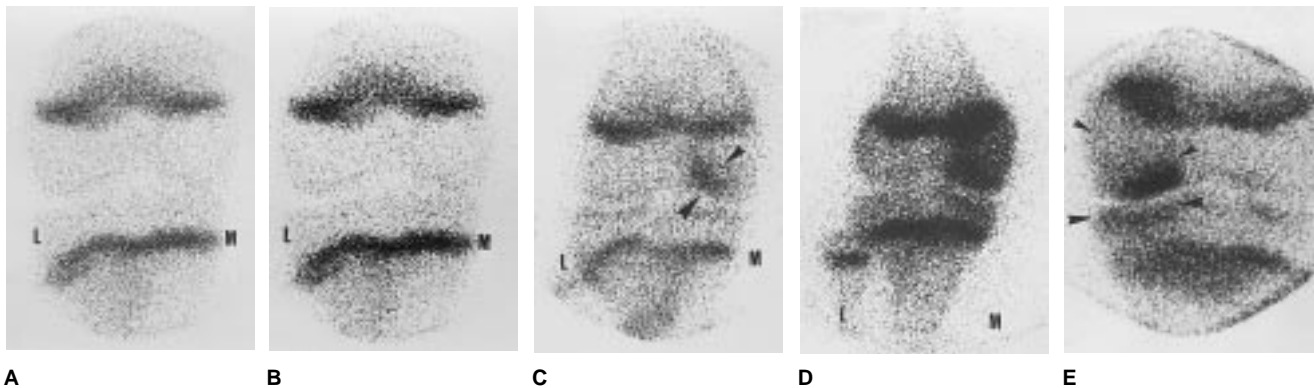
Scintigraphic appearance of JOCD (L indicates lateral aspect; M, medial aspect). In this scintigraphic classification, stages II, III and IV are additive. A, Stage 0. Note the normal activity of the physal plate. B, Stage I scans are scintigraphically normal. This particular scan could be depicting an accessory center of ossification or a healed JOCD defect. C, Stage II scans show the first degree of scintigraphic abnormality. On this scan, the medial femoral condyle has a JOCD lesion (arrowheads) of mid- to low-level scintigraphic activity. If this were a preoperative scan, a bone graft should be part of the procedure, since the degree of vascular activity indicated by the scan is marginal. D, In this stage III scan, not only the lesion but the entire femoral condyle shows increased uptake. E, Stage IV scans exhibit the highest degree of scintigraphic activity. Note the increased uptake in the adjacent tibial plateau, which is likely due to the same process that produces the femoral lesions, namely, increased cumulative stress transfer causing tibial subchondral stress fractures. The intense lesion uptake (arrowheads) indicates that bone grafting to increase vascularity would not be necessary. (Reprinted with permission from Cahill BR, Berg BC: 99m-Tc-hydroxymethylene diphosphonate compound joint scintigraphy in the management of juvenile osteochondritis dissecans of the femoral condyles. *Am J Sports Med* 1983;11:329-335.)
